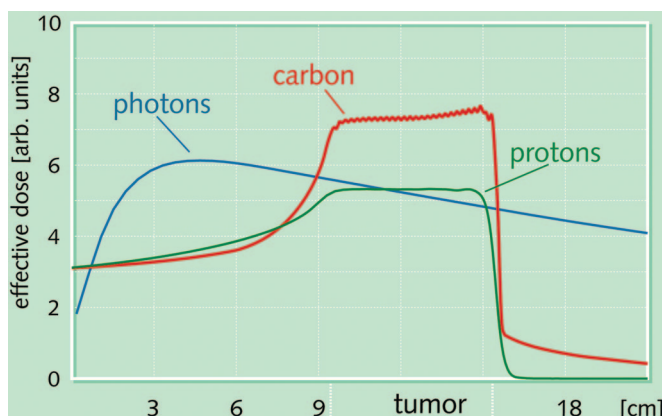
Effective depth-dose curves of three beams: photon (x-ray), carbon ion, and proton. The effective dose includes both the absolute dose and radiobiological effectiveness of the beams in killing cells. A tumor is denoted on the x axis at a depth of 12 to 15 cm from the surface of the patient. The photon beam delivers a greater proportion of its dose both superficial and deep to the tumor than the other beams. The carbon ion beam delivers a greater effective dose than the proton beam to the tumor for a given entrance dose. In addition, there is a slightly greater exit dose for the carbon ion beam than the proton beam. (Available at: http://www.gsi.de/portrait/Broschueren/Therapie/Krebstherapie_e.html. Reproduced with permission of Gesellschaft für Schwerionenforschung.)
